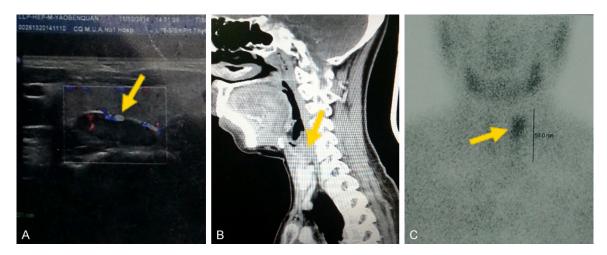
Findings of B-ultrasonic testing, CT and SPECT scan of parathyroid. A: Longitudinal B-ultrasonic image of parathyroid adenoma at upper left. Arrow showed oval hypoecho mass posterior to the left lobe of thyroid gland with a size of 2.1×1.2 cm, homogeneous cytoplasm, well-defined boundary and visible capsule. B: Sagittal CT image of parathyroid adenoma at upper right. The arrow showed isopycnic mass posterosuperior to the right lobe of thyroid gland, with a size of 0.9×0.6 cm and well-defined boundary. The adenoma showed enhancement after contrast agent injection, but the enrichment degree was lower than that of normal thyroid gland. C: Delay-phase SPECT image of parathyroid adenoma at upper left. The arrow showed that the nodule superior to the thyroid gland was continuous, while the development the lower left lobe and the whole right lobe was reduced.
